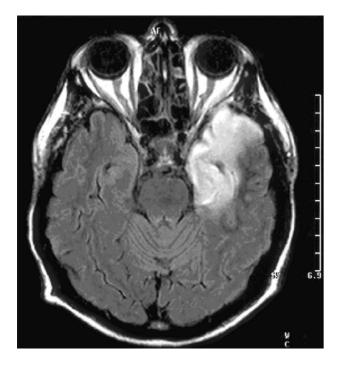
The MRI revealed a hyperintensity of the left temporopolar and temporo-medial lobes (FLAIR-Image) [29].
